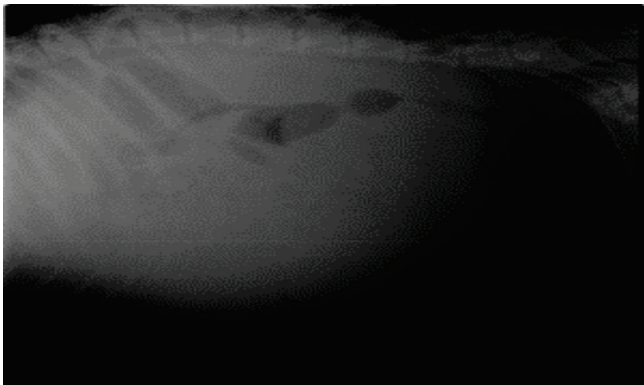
X-ray of abdomen showing ground glass appearance indicating free fluid in abdominal cavity.
